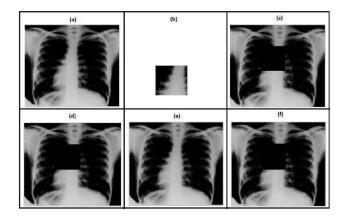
(a) The original host X-Ray image, (b)ROI image of host image,(c)Roi removed image (c)Emebedded image without ROI, (d)Final embedded image with ROI
